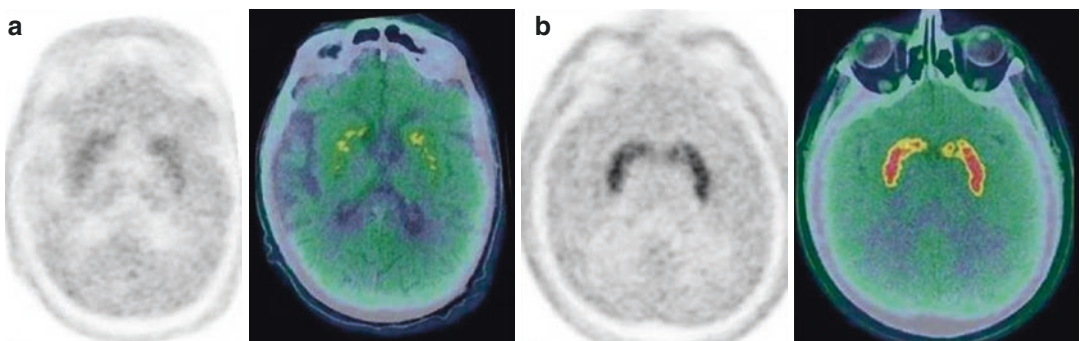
In a 60-year-old patient with Parkinson's disease, axial ¹⁸F-DOPA PET and PET/CT views (a) show diffuse reduction of the uptake in putamen and caudate
